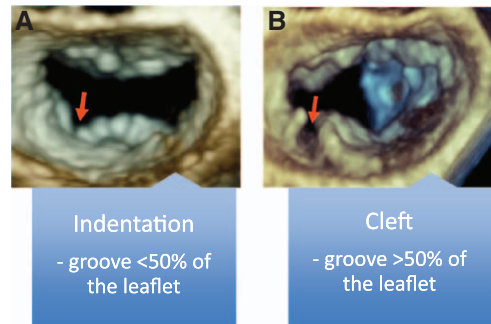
Recognition and differentiation of mitral valve indentations and clefts. Zoomed 3-dimensional transesophageal echocardiography images of the mitral valve, as seen from the left atrium with the anterior leaflet located at the 12 o'clock position, demonstrating a posterior leaflet indentation (left) and a posterior leaflet cleft (right).
